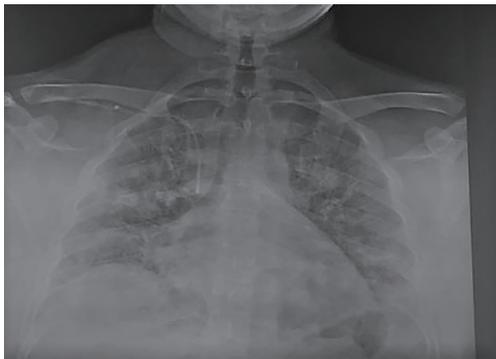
Chest X-ray of the patient showing bilateral interstitial opacity which when confronted with the clinical picture was suggestive of acute respiratory distress syndrome.
